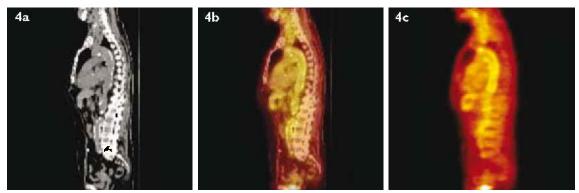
(a) Reconstructed MPR sagittal CT image of the thorax and abdomen shows multifocal and segmental calcifications along the wall of arch and descending aorta. (b) The fused image confirms the location of increased 18F-FDG on the wall of the descending aorta, and the (c) PET image also shows avid activity along the wall of the descending aorta.
